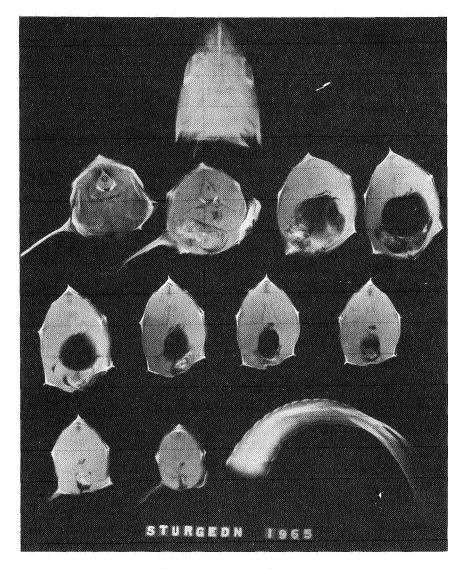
Roentgenographs of cross sections of the entire length of the sturgeon shown in figure 56. Note the location of deposits of calcified tissue in the base of the chondrocranium, but none elsewhere in the endoskeleton. The bony plates in the exoskeleton encase the entire body in armor.
